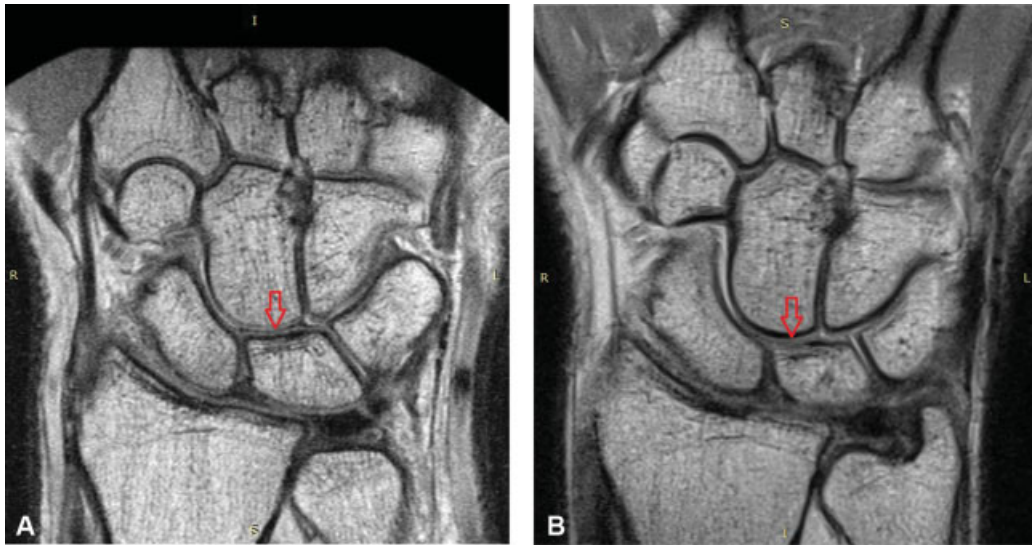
Intercarpal cartilage: dedicated extremity MRI (A) versus conventional MRI (B).
